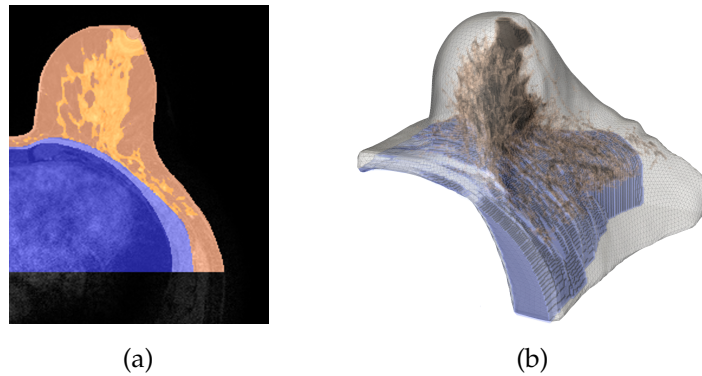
Patient specific biomechanical model generated from segmented MR image. (a) The different tissue classes are adipose (brown), fibroglandular tissue (orange), pectoral muscle (light blue) and chest (dark blue) and are used to define appropriate material properties to the biomechanical model (b).*
